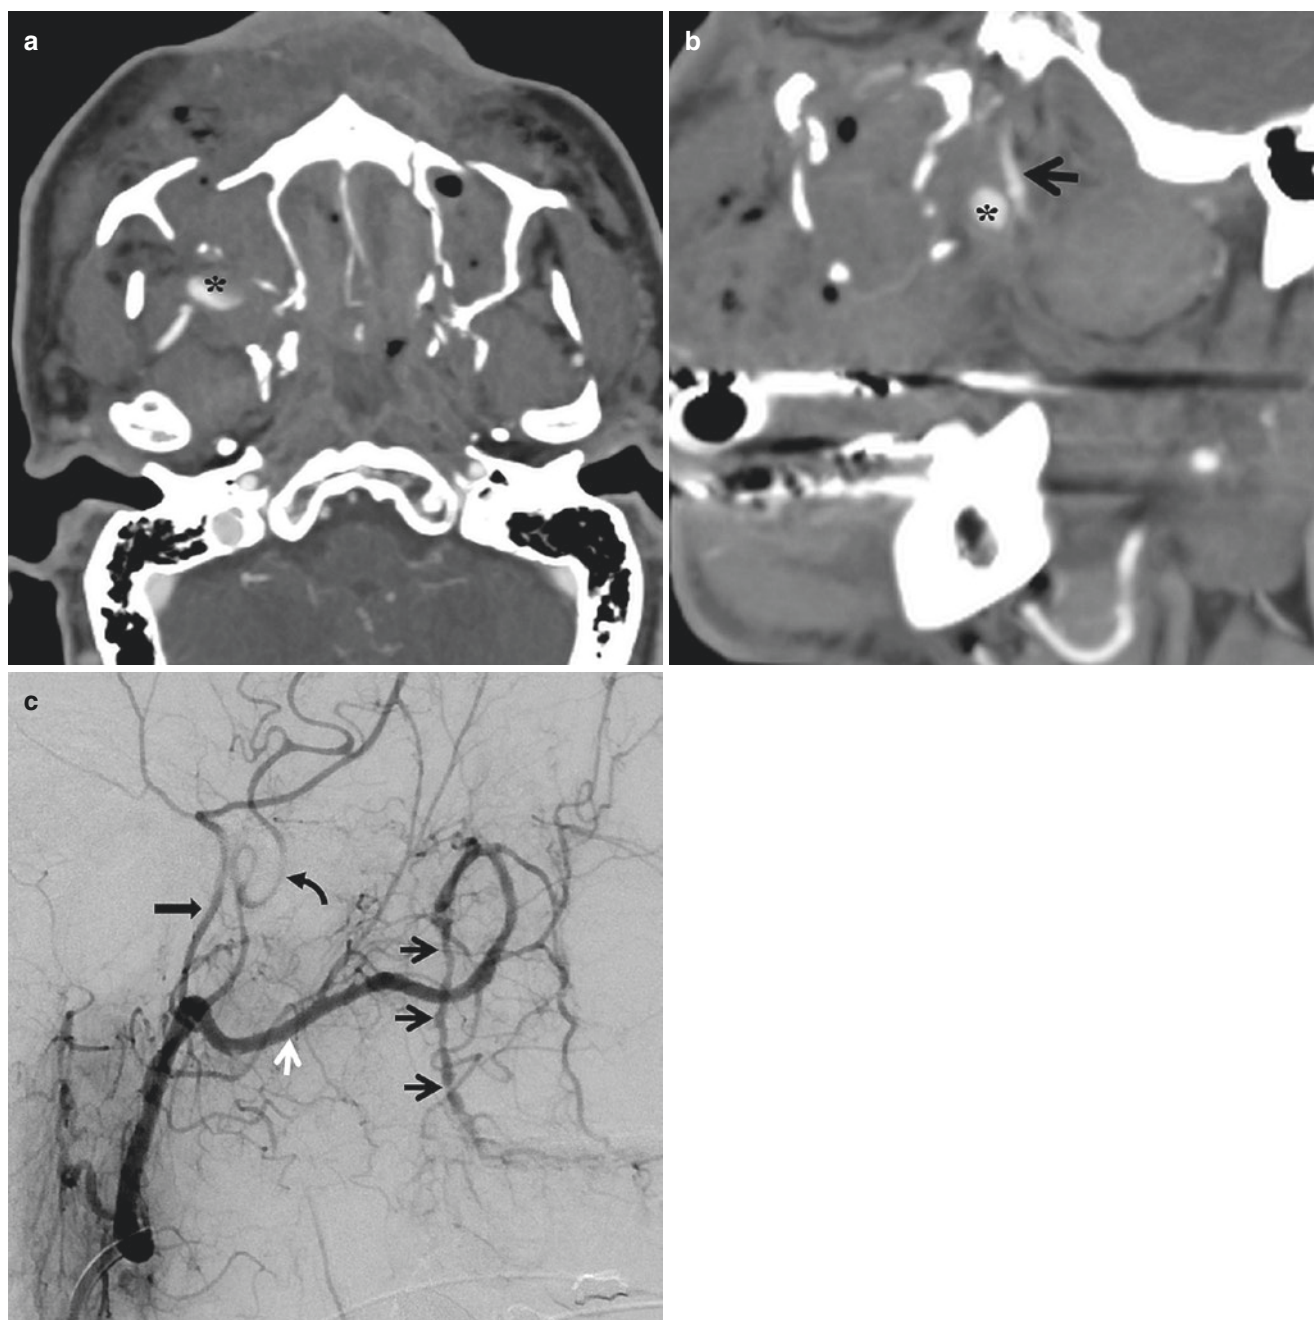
Traumatic injury of internal maxillary artery. Trauma patient with bilateral LeFort 3 fractures and uncontrollable epistaxis. (a) Axial CTA demonstrates active extravasation (*) posterior to the fractured right maxillary sinus. (b) Sagittal CTA shows the hemorrhage is adjacent to the descending palatine artery (arrow), a distal branch of internal maxillary artery. (c) Selective injection of external carotid artery
